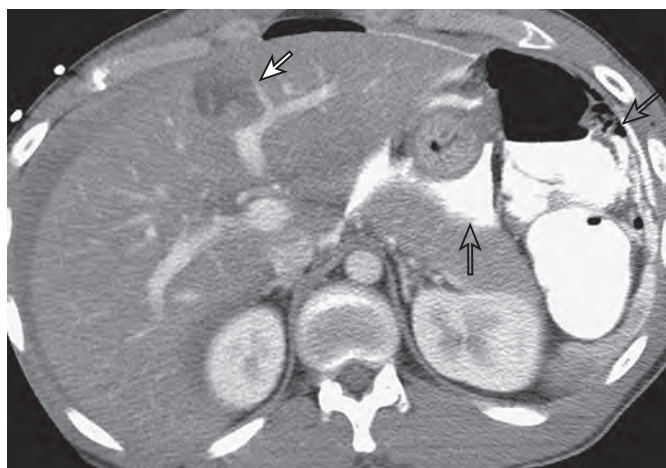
Unsuspected hepatic laceration secondary to a gunshot to the left upper abdomen resulting in colonic perforation. CT demonstrates a low-density laceration in the left hepatic lobe (solid arrow). Free air and extravasated rectal contrast material are also seen, indicating bowel perforation (open arrows).
